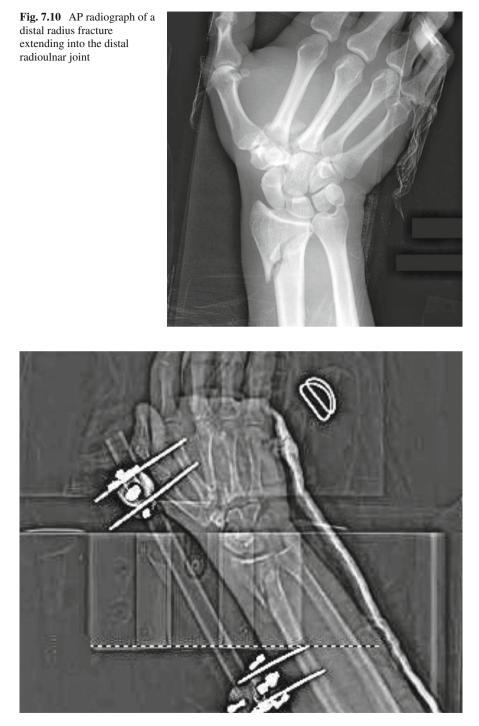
AP radiograph of a distal radius fracture with extension into the DRUJ following reduction and fixation with a bridging monotubular external fixator
